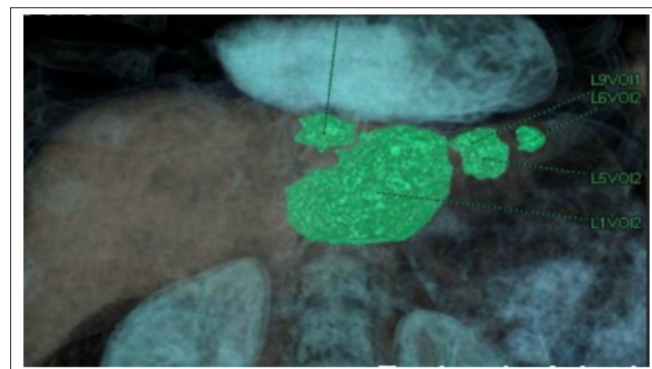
Three-dimensional reconstruction of positron emission tomography (PET/CT scan with 18F-FDG). Multiple areas of radiotracer (FDG) hyperuptake highlighted in green, including a hepatic lesion located in segment VI
